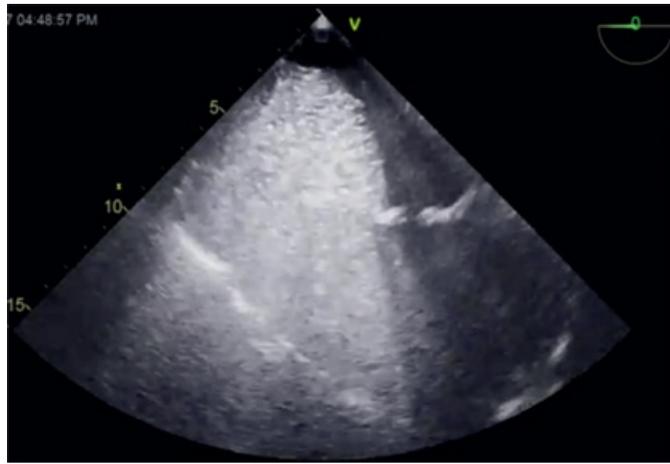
Transesophageal echocardiogram (TEE) image demonstrating coalescing echogenic foci filling the right atrium and ventricle, consistent with a CO₂ embolism [9].
